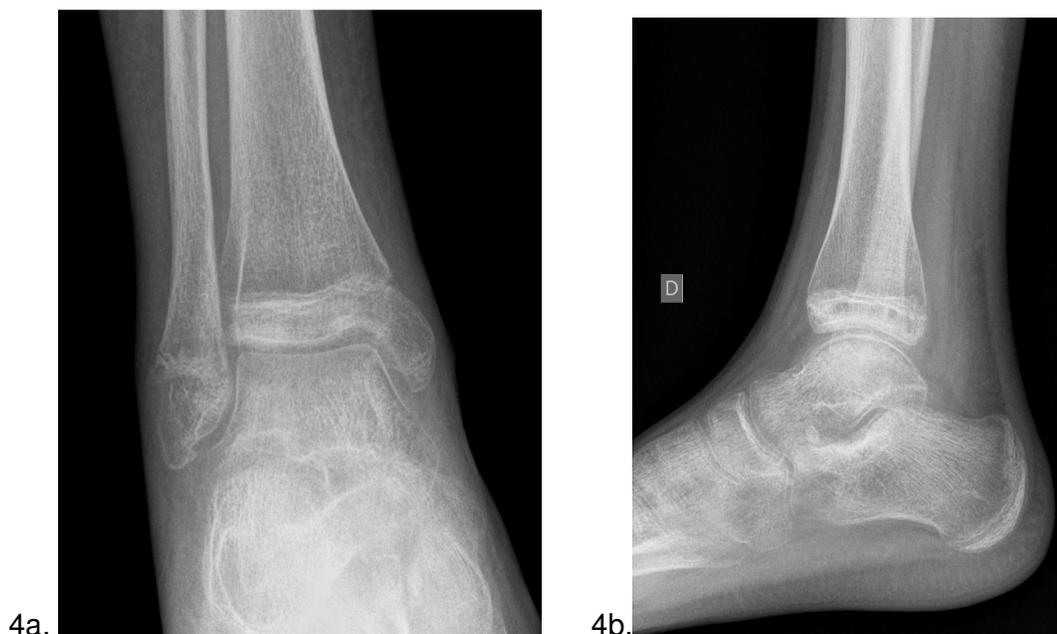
and 4b X-ray at 6 weeks postoperatively
